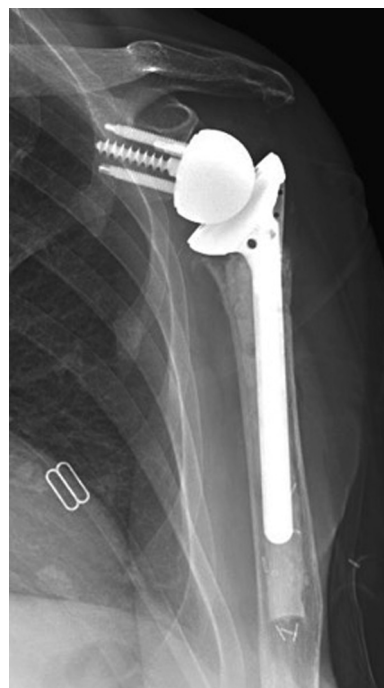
The six-month postoperative anteroposterior radiograph after index procedure demonstrating greater tuberosity resorption.
